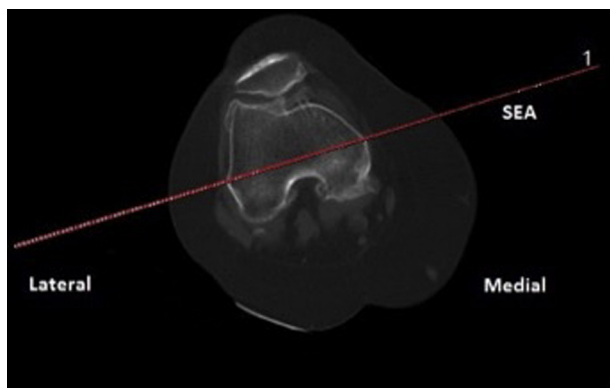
Axial CT image in which line 1 (denoted in Red color) connects the sulcus of the medial femoral epicondyle to the lateral epicondyle. This is called the 'Surgical Epicondylar Axis' (SEA).
